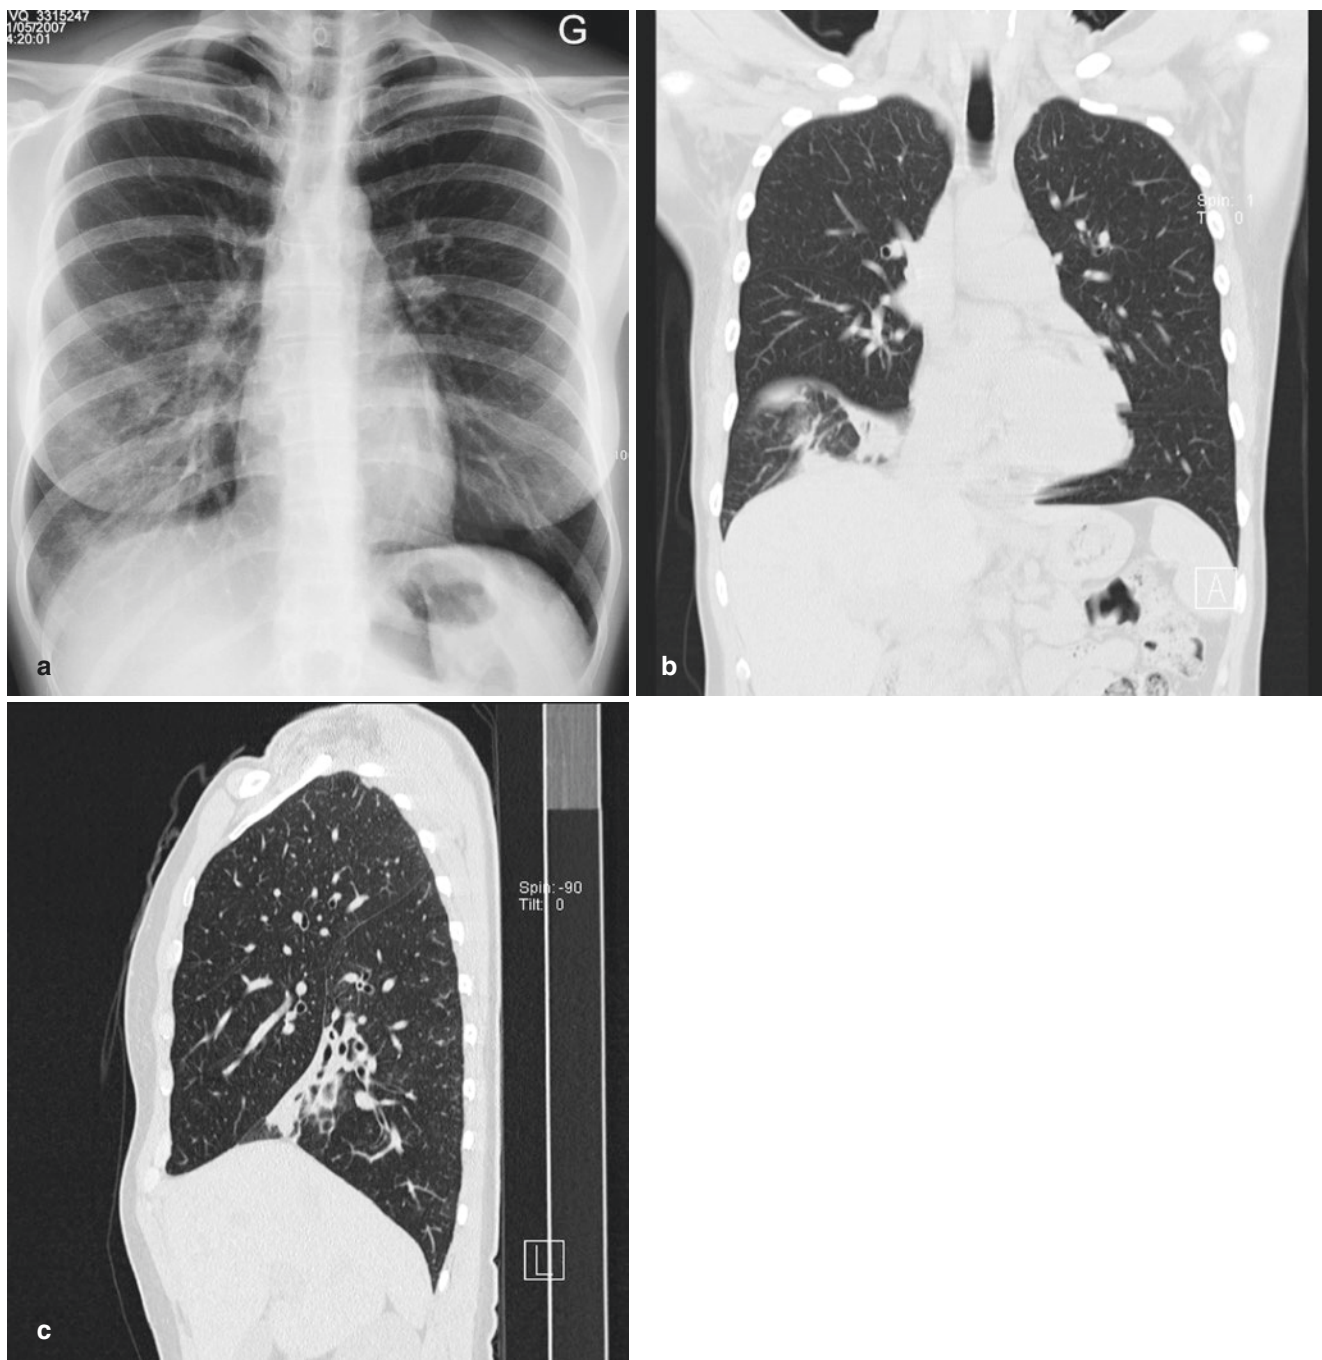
A 46-year-old woman with cough and right-sided chest pain. Postero-anterior radiograph interpreted as normal (a). Coronal (b) and sagittal (c) reformats showing consolidation in the anterior segment of the right lower lobe
